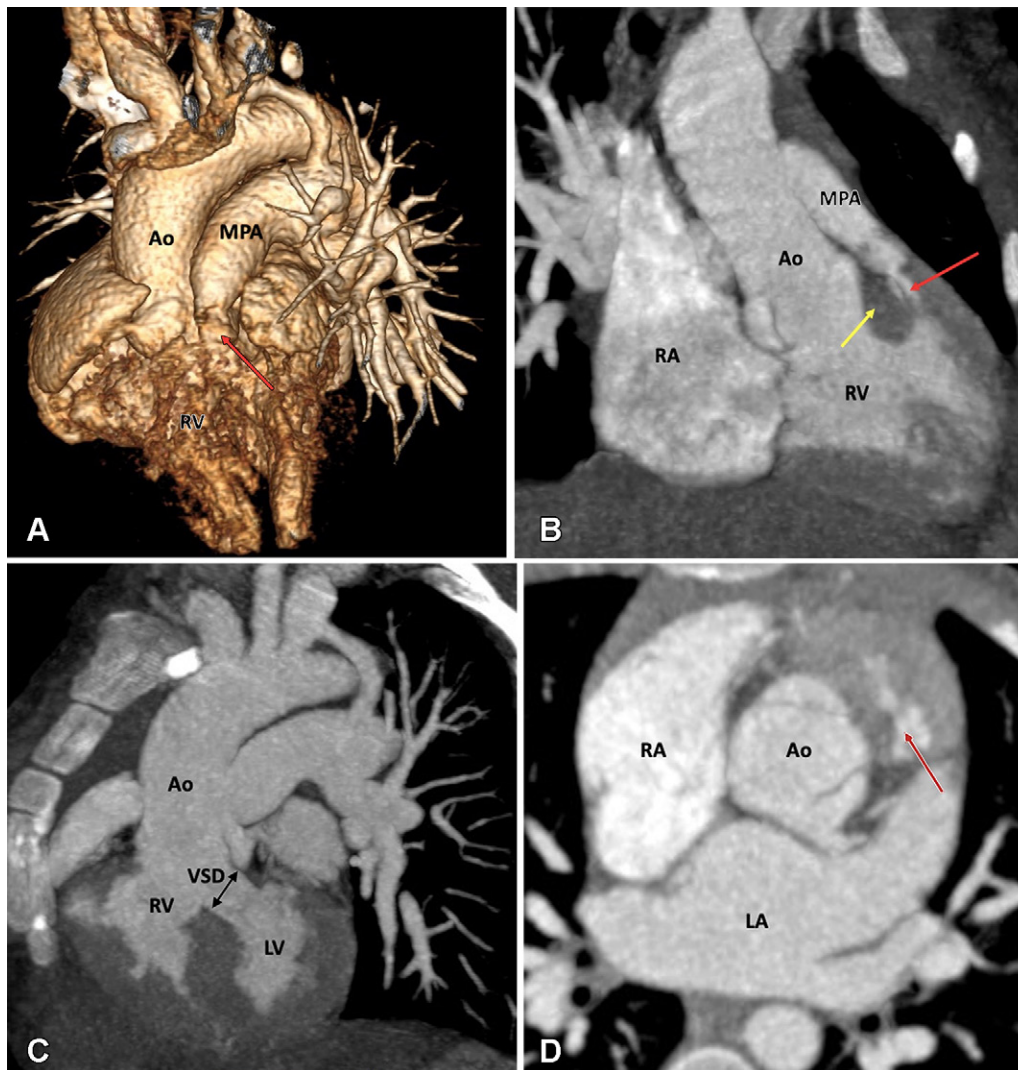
Preoperative appearance of TOF-type DORV in a 2-month-old male infant. (A) Volume-rendered image and (B) coronal oblique maximum intensity projection (MIP) CT image show the great arteries arising from the RV. Severe pulmonary stenosis is seen (red arrow). Note the subpulmonic conus (yellow arrow in B). (C) Sagittal MIP CT image shows the subaortic VSD (black double arrow). (D) Axial reformatted MIP CT image shows the normal relationship of the great vessels; the aorta is situated posterior and rightward to the pulmonary trunk. There is hypertrophy of the pulmonic infundibulum, causing severe RVOT stenosis (red arrow). Ao = aorta, DORV = double-outlet right ventricle, LA = left atrium, LV = left ventricle, MPA = main pulmonary artery, RA = right atrium, RV = right ventricle, RVOT = right ventricular outflow tract, TOF = tetralogy of Fallot, VSD = ventricular septal defect.
